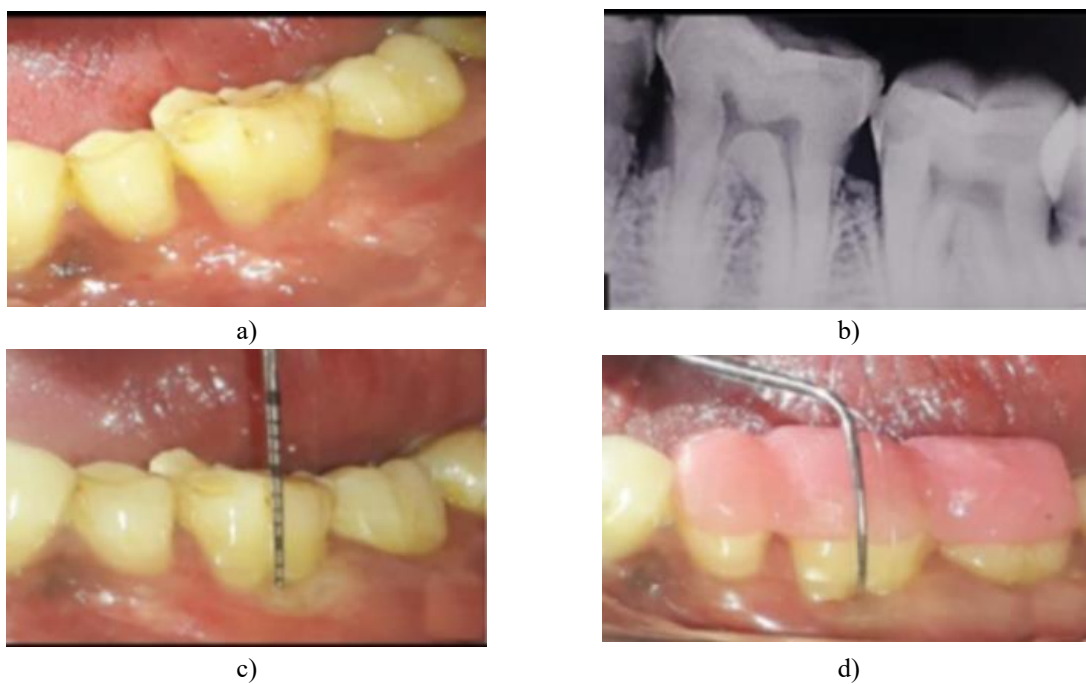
(a) Post-operative image of test site, (b) Post-operative intraoral periapical radiograph of the tooth with grade II furcation, (c) Postsurgical measurements of vertical probing depth, (d) Postsurgical measurements of horizontal probing depth
